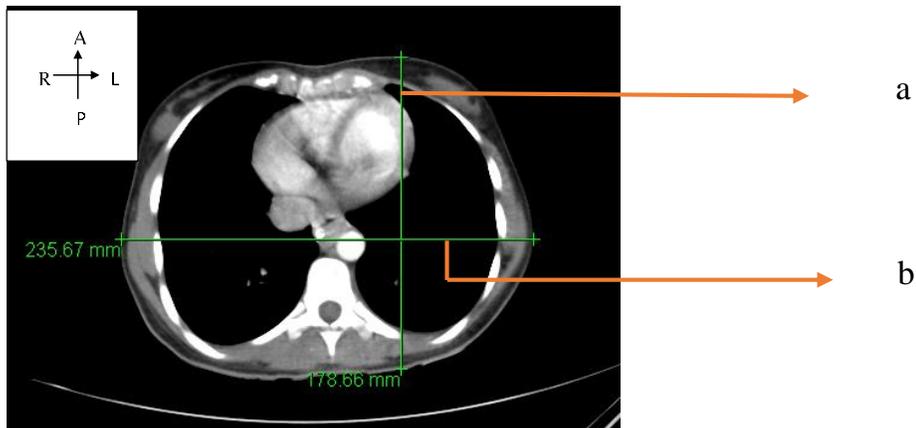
CT Thorax- Measurements of Tomographic Image- At Base of Lung (Level T3)
